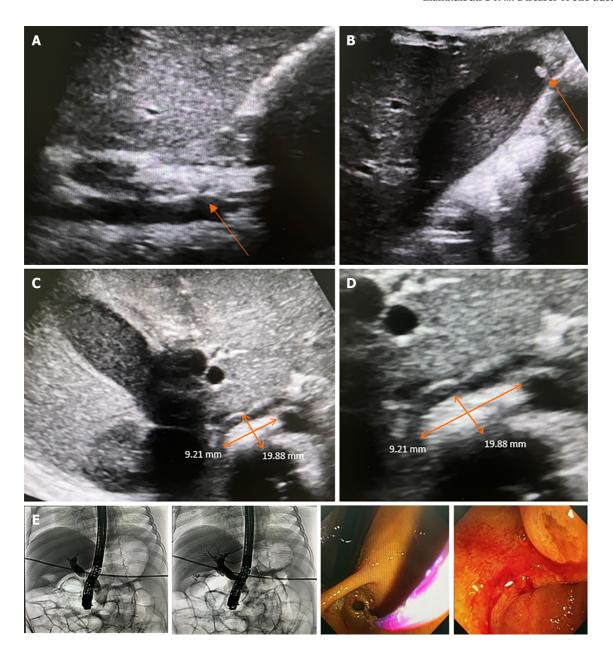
A 2-month-old female infant with anemia caused by chronic hemolysis. Genetic analysis demonstrated heterozygous PKLR1 mutation/large deletion that was compatible with pyruvate kinase deficiency. Subsequently, she received regular blood transfusions every 3-4 wk. At the age of 3 years, the patient experienced intermittent abdominal pain, nausea, jaundice, and decreased appetite with no fever. Liver function test showed total bilirubin (TB) of 33.4, direct bilirubin (DB) of 31.2 mg/dL, aspartate aminotransferase of 270, alanine transaminase of 530, and alkaline phosphatase of 277 U/L. Abdominal ultrasonography showed marked splenomegaly, a dilated common bile duct (CBD) up to 0.9 cm in diameter, mild wall thickening, a suspected 2 cm × 0.9 cm distal CBD stone - well-distended gallbladder with bile sludge, and a 0.4 cm gallstone in the fundus. Subsequently, endoscopic retrograde cholangiography (ERCP) was performed, which revealed a bulging ampulla and CBD dilatation of 1 cm. The CRE balloon (12-15 mm) filled with 40 mL of air was placed for 60 s for sphincteroplasty. Later, balloon sweeping was performed, and small, blackish-pigmented stones were observed. After stone removal, the liver function test improved gradually as TB/DB 7.84/4.57 at 1 wk and normal values at 1 month. A: Dilated CBD, up to 9 mm, with mild wall thickening; B: A well-distended gallbladder with bile sludge and 0.4 cm stone at the fundus; C: A 2 cm × 0.9 cm distal CBD stone; D: A 2 cm × 0.9 cm distal CBD stone (zoom in); E: ERCP with CBD dilation with 12-15 mm CRE balloon filled with 40 mL of air placed for 60 s as sphincteroplasty.
